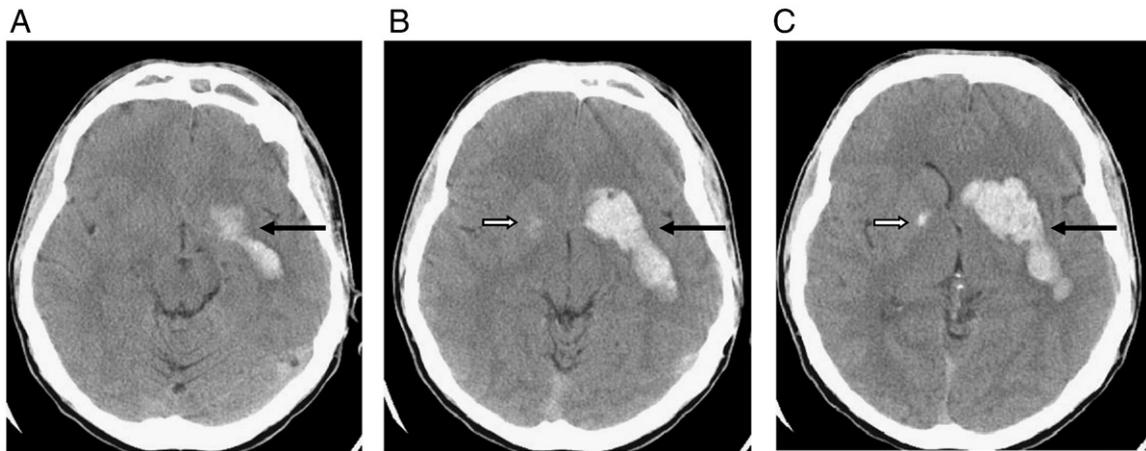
Axial CT images (A, B, C) showing an intraparenchymal haemorrhage in the left striatum nucleus (black arrow) involving part of the temporal lobe. The light hyperdensity in the right globus pallidus represents a calcification (white arrow).
